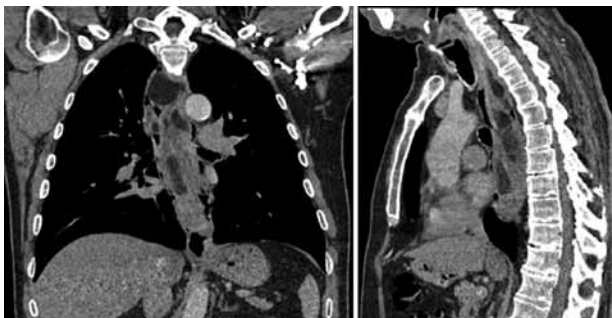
Coronal (a) and sagittal (b) chest CT images showing an 18cm long, fat-density lesion along the oesophageal wall. Neither direct invasion to adjacent structures nor mediastinal lymphadenopathy was noted.
